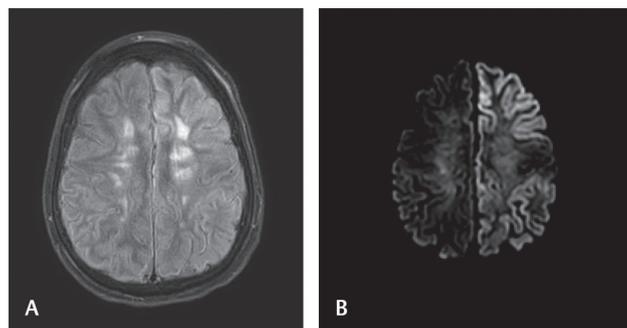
Second magnetic resonance imaging brain fluid-attenuated inversion recovery (FLAIR) sequences for Case 2, showing nonenhancing FLAIR hyperintensities in the (A) right parietal lobe and (B) left inferior frontal lobe.
